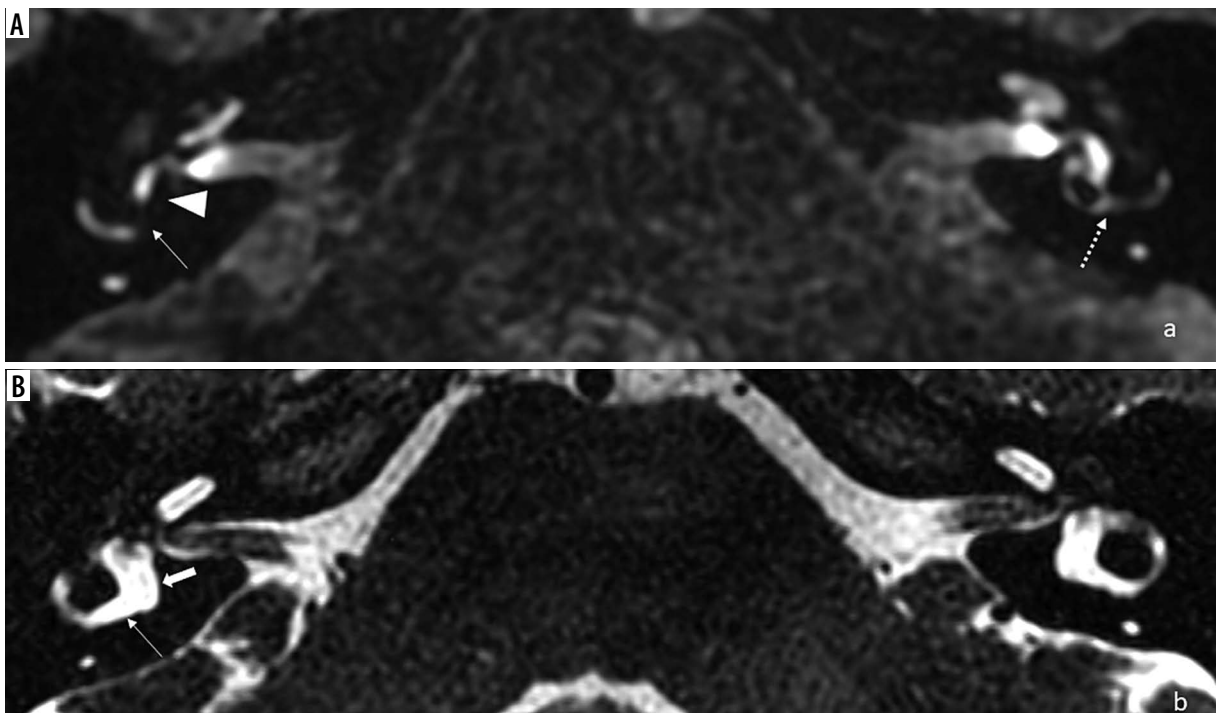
Magnetic resonance images of a 45-year-old male (patient #6) with right-sided clinically defined Ménière's disease. The example case of grade 2 vestibular hydrops according to the Barath classification [11] and grade 3 in the Bernaerts scale [13]. A) Delayed-postcontrast 3D-FLAIR T2 axial image of both ears below the mid-modiolar level (inferior part of the vestibule). No enhancing perilymphatic vestibular space is seen on the right. It is entirely encompassed by the widened, confluent endolymphatic saccule and utricle (marked with arrowhead). The endolymphatic hydrops herniation into the lateral semi-circular canal's posterior crus is visible (marked with an arrow). On the left side, the non-affected ear, the lateral semi-circular canal is preserved (marked with a dotted arrow). B) 3D-FIESTA axial image of both ears. Normal anatomy of the fluid-filled inner ear structures is visualized. The vestibule is marked with a thick arrow, posterior crus of the lateral semi-circular canal is marked with a thin arrow
